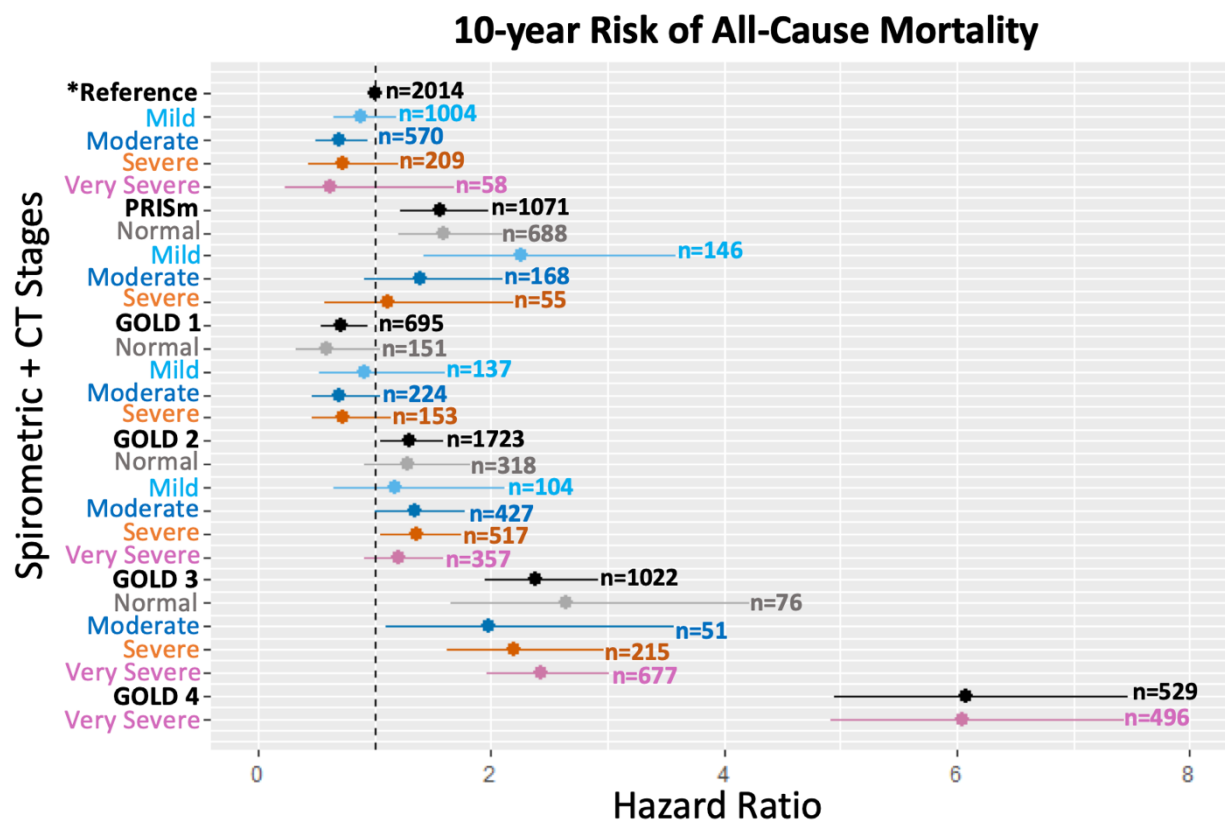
Mortality hazard ratios for CT-based stages within their respective GOLD stage categories were not significantly different from each other.
